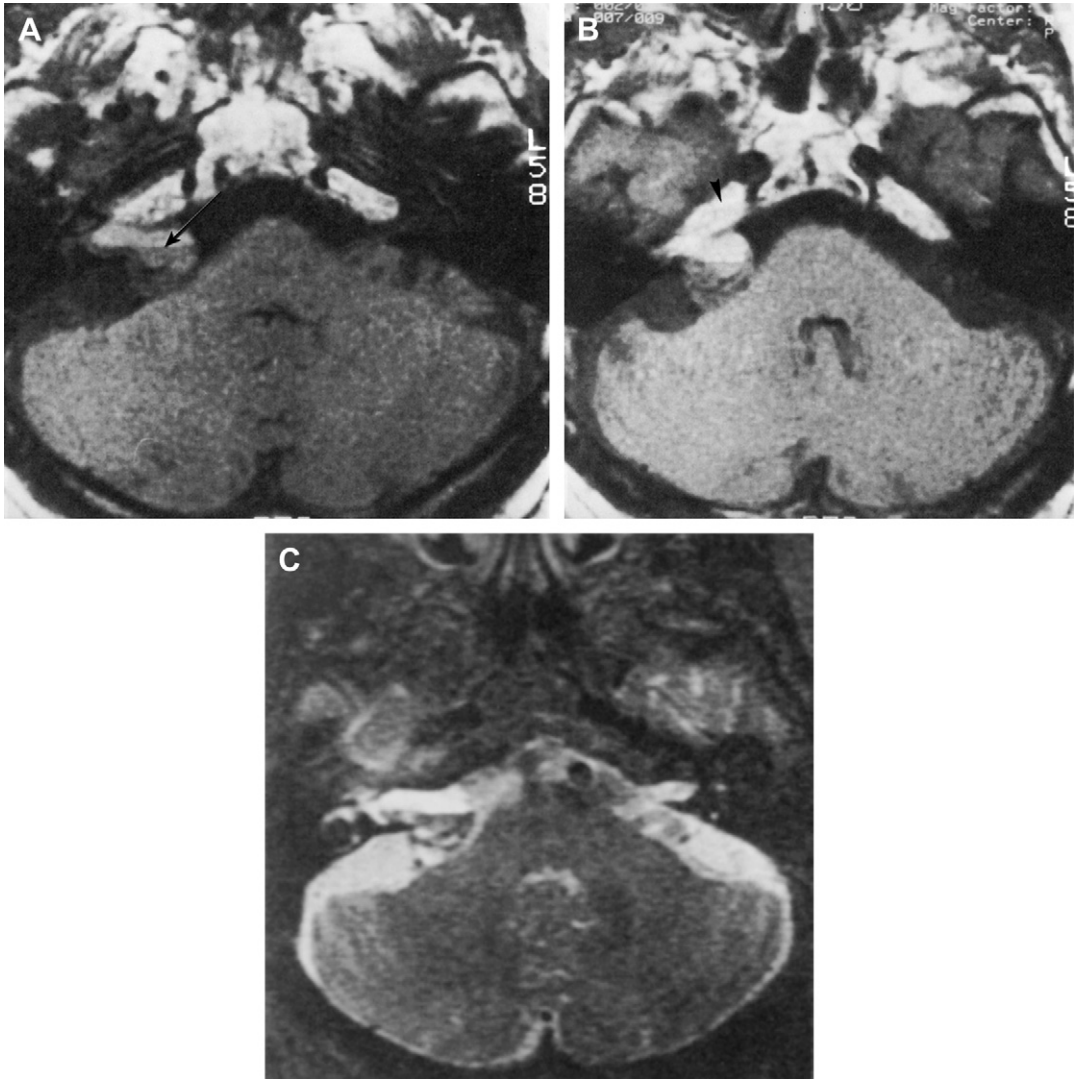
Hemorrhage into an acoustic neuroma. This patient had an acoustic neuroma diagnosed previously. The patient had an acute hearing loss and underwent magnetic resonance imaging. At surgery the patient had a large hemorrhage into the acoustic neuroma. (A) T₁-weighted (TR 600/TE 20) image shows an acoustic neuroma on the right side with apparent fluid/fluid level (*arrow*). (B) T₁-weighted image slightly superior to that found in A, again shows fluid level representing layering of hemorrhage. Also note the bright signal (*arrowhead*) in the fat of the petrous apex. (C) T₂-weighted image showing even greater contrast between the fluid components of the hemorrhage.
